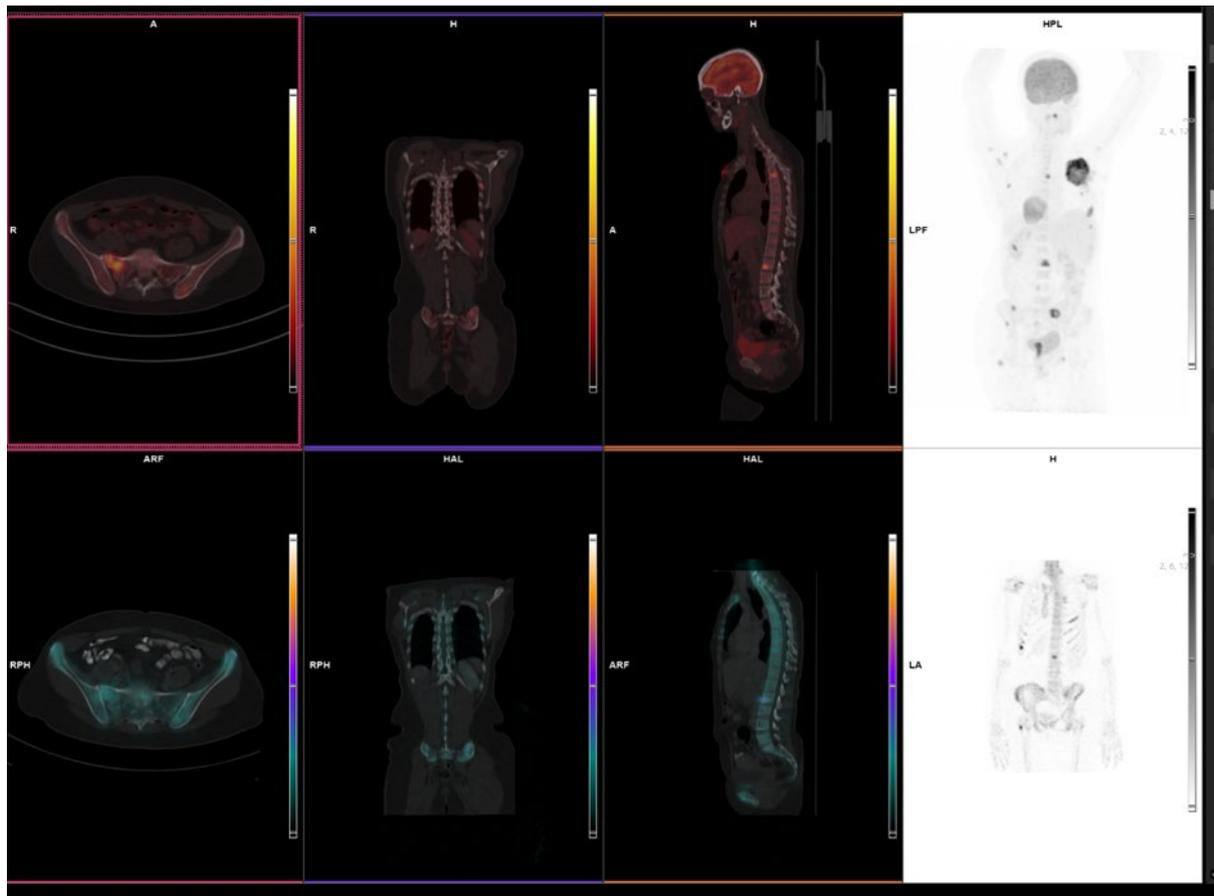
43-year-old female diagnosed with breast cancer. Images demonstrating more skeletal lesions on FDG PET/CT (row above) in comparison to bone scan (row below).
